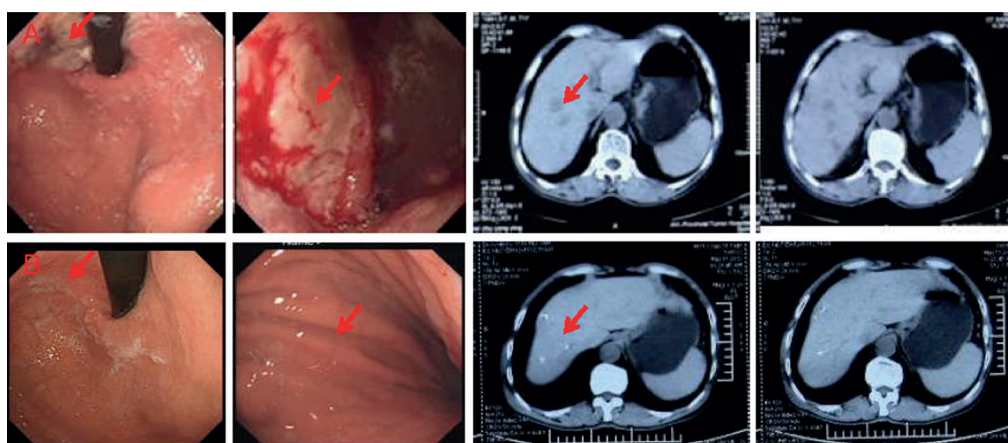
Typical case 4. Comparison of electron gastroscopy and CT images before (A) and after (B) intervention.
